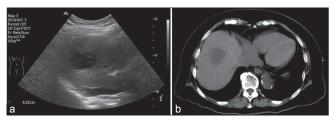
The secondary admission showed an irregular hypoechoic lesion over the S8 segment by abdominal ultrasonography (a) and abdominal computed tomography (b)
